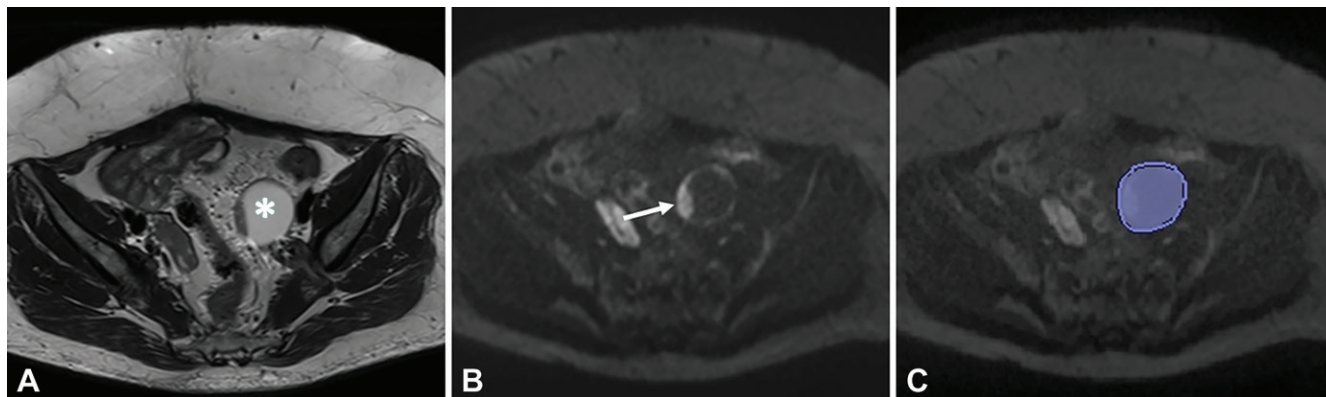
Images in a 51-year-old woman with fibroma of left ovary. A, Transversal T2-weighted MR image (repetition time msec/echo time msec, 5170/78) shows mixed cystic-solid lesion (*). B, Transversal diffusion-weighted MR image (9200/59) obtained at $b = 1500 \text{ sec/mm}^2$ shows high signal intensity of solid tissue (arrow). C, Same image with manual segmentation (blue region of interest) of entire lesion on selected transversal slice.
